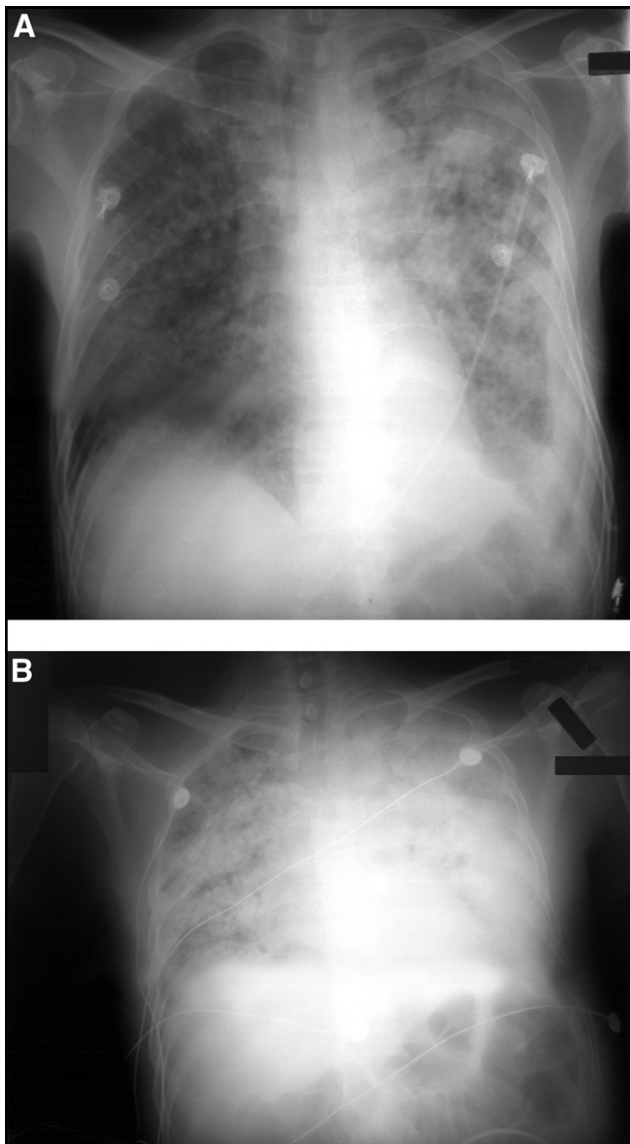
Admission chest radiograph demonstrating bilateral airspace disease and interstitial infiltrates in a patient with acute pulmonary TB (A). Within 24 hours, the patient developed respiratory failure (B) requiring intubation.
